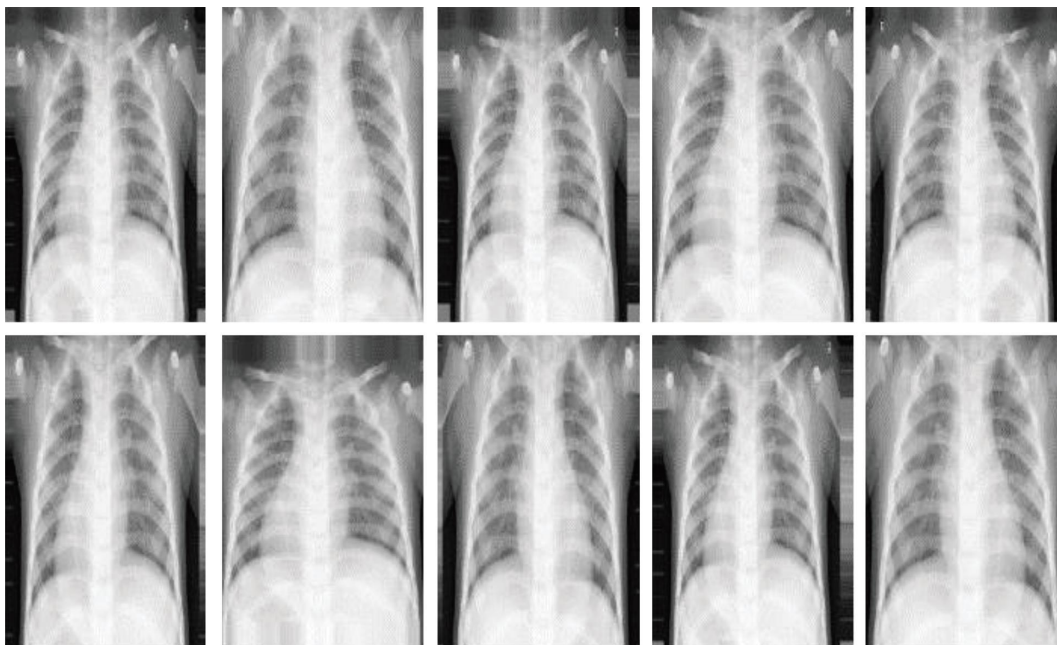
Variations of a chest X-ray image.
